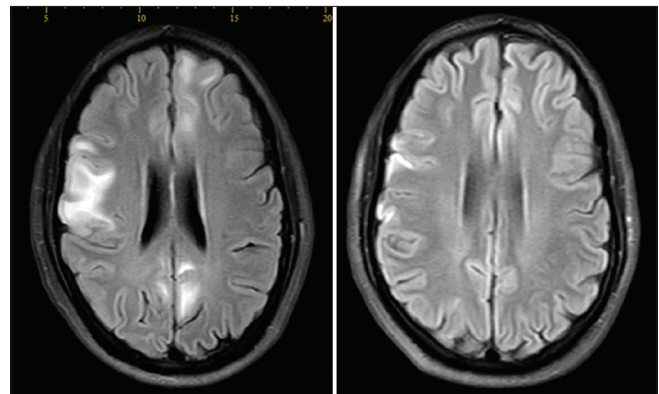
Contrast magnetic resonance imaging pre- and post-therapeutic plasma exchange
